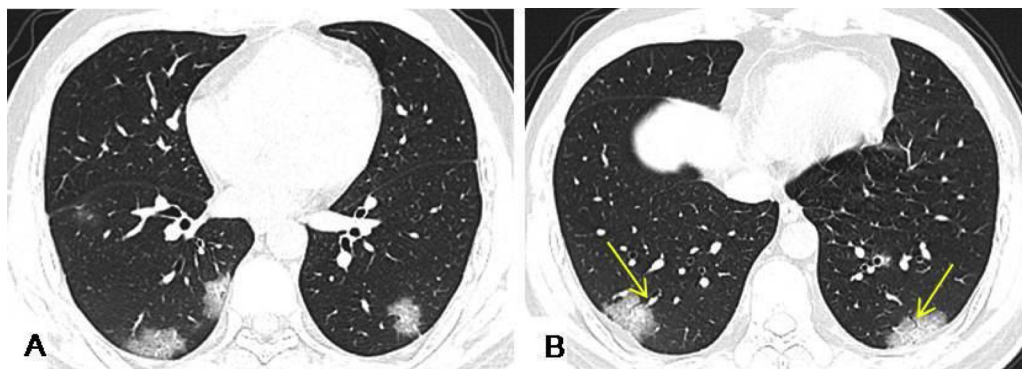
A 34-year-old male had an 8-day history of fever with fatigue and generalized aching. HRCT scans showed multiple GGO accompanied with interlobular septa thickening, and crazy paving pattern in the bilateral lower lobes under the pleura. Air bronchogram signs (yellow arrows) in the GGO were observed in bilateral lower lobes.
